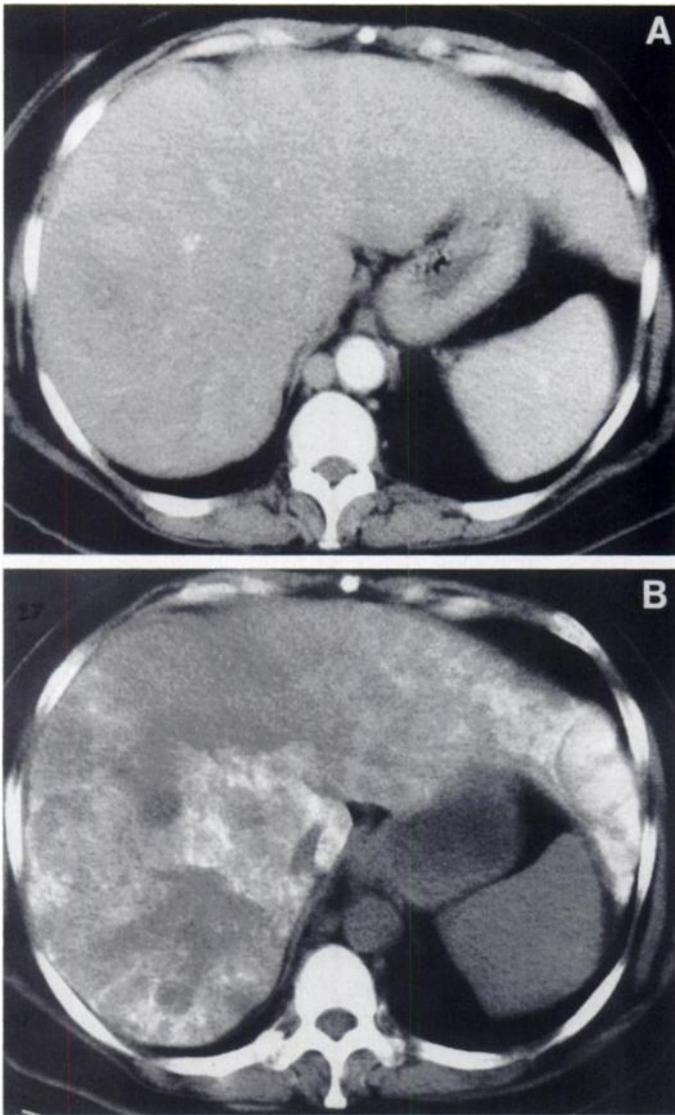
Comparison of CT before (A) and 1 day after (B) injection of lipiodol into the hepatic artery. After lipiodol injection, tumor visualization, in accordance with the surgical findings, was obtained.
